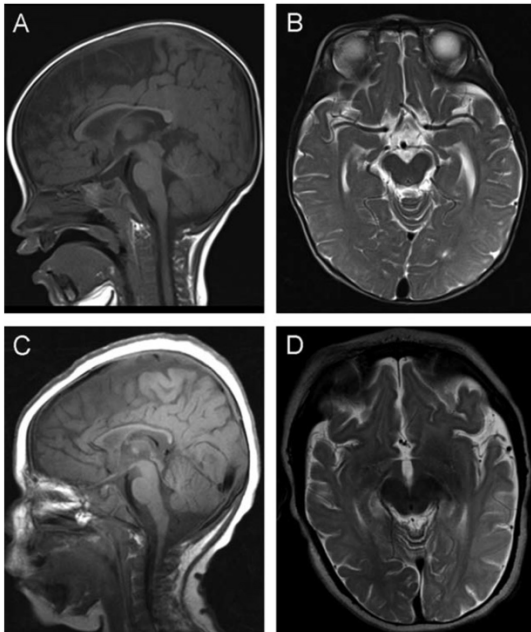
Brain findings in *APP* knockout. (A) One-year-old male normal sagittal T1 magnetic resonance imaging (MRI) demonstrating normal myelination and corpus callosum thickness and (B) axial T2 MRI demonstrating lack of focal atrophy and normal T2 signal in subcortical white matter of the left temporal and occipital regions. (C) Proband sagittal T1 MRI demonstrating diffuse hypomyelination with thin corpus callosum and (D) axial T2 MRI demonstrating focal atrophy and hyperintense T2 signal in subcortical white matter of the left temporal and occipital regions.
